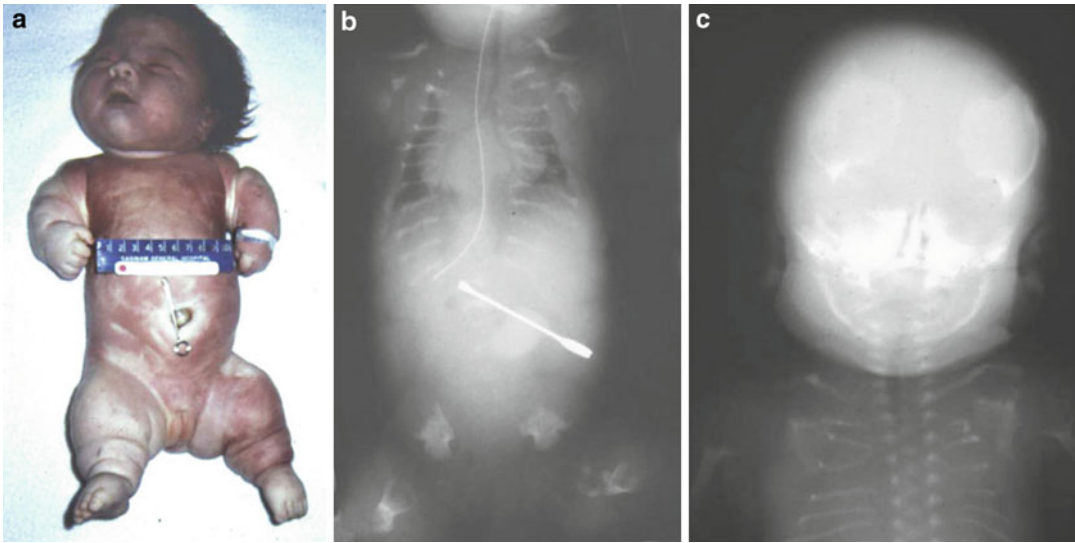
(a–c) A neonate with perinatal lethal form of hypophosphatasia showing severe shortening of limbs. Radiograph shows markedly deficient ossification and abnormal bone development similar to achondrogenesis type I
